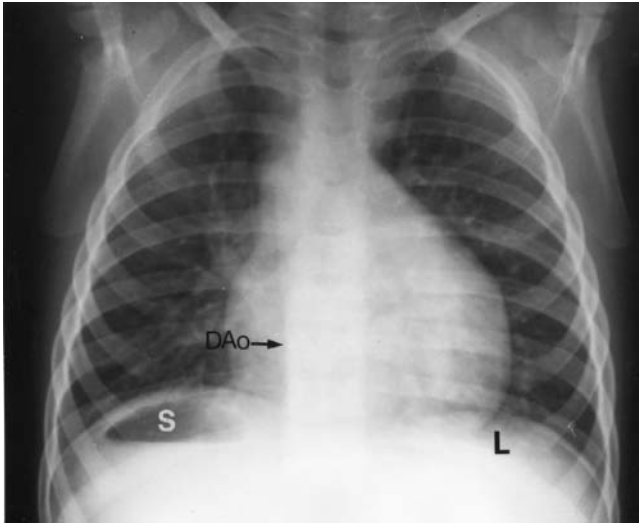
X-ray from a 16-year-old male in *situs inversus* with *levocardia*. The stomach (S) is on the right and the liver (L) is on the left, but the cardiac apex is on the left. Accordingly, the left hemidiaphragm is lower than the right hemidiaphragm because the apex is on the left. The descending aorta (DAo) is concordant for *situs inversus*, but the position of the ascending aorta indicates a discordant d-bulboventricular loop.
